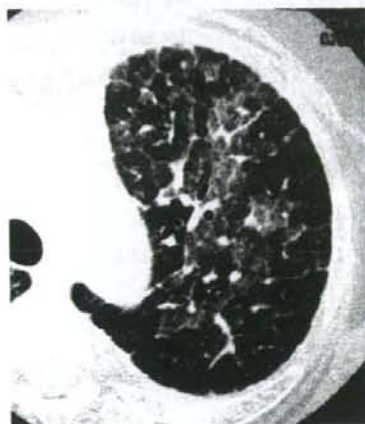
GGO seen in a RA-PCP patient. A 71-year-old woman had received MTX therapy for 6 years. PCP was diagnosed based on elevated β -D-glucan and positive PCR for *P. jirovecii* in bronchoalveolar lavage fluid. CT shows type A GGO.
